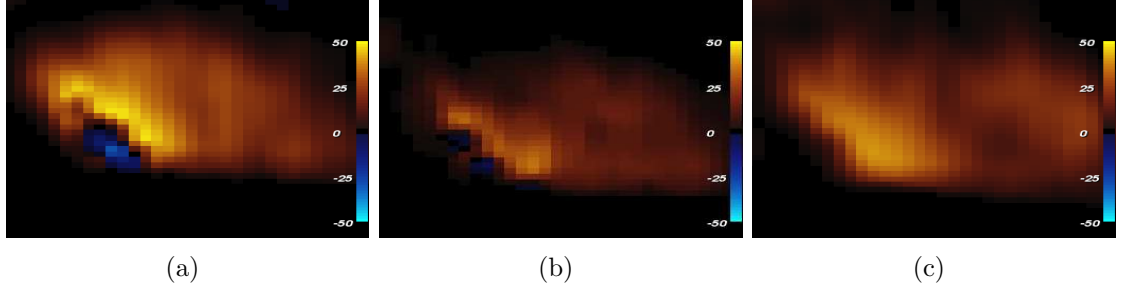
Variation in real colour Doppler images. (a)–(c) Slice of three real colour Doppler images acquired consecutively from the same view and at a similar time frame, showing unintended variations that occur in scan-converted colour Doppler images.
